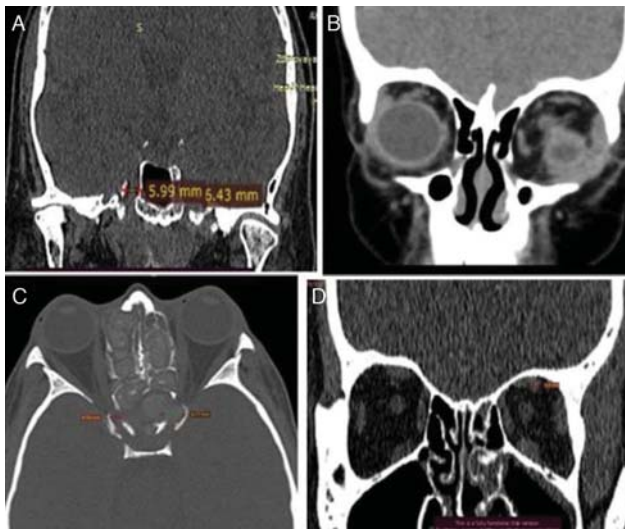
MSCT. (A) Coronal projection. Expansion of the left cavernous sinus. (B) MRI. Coronal projection. Endophthalmitis, exophthalmos on the left. S. MSCT. (C) Axial projection. Pansinusitis, expansion of the cavernous vein on the right. (D) Coronal projection. Dilation / thrombus of the superior ophthalmic vein on the left. MRI, magnetic resonance imaging; MSCT, multi-slice computed tomography.
